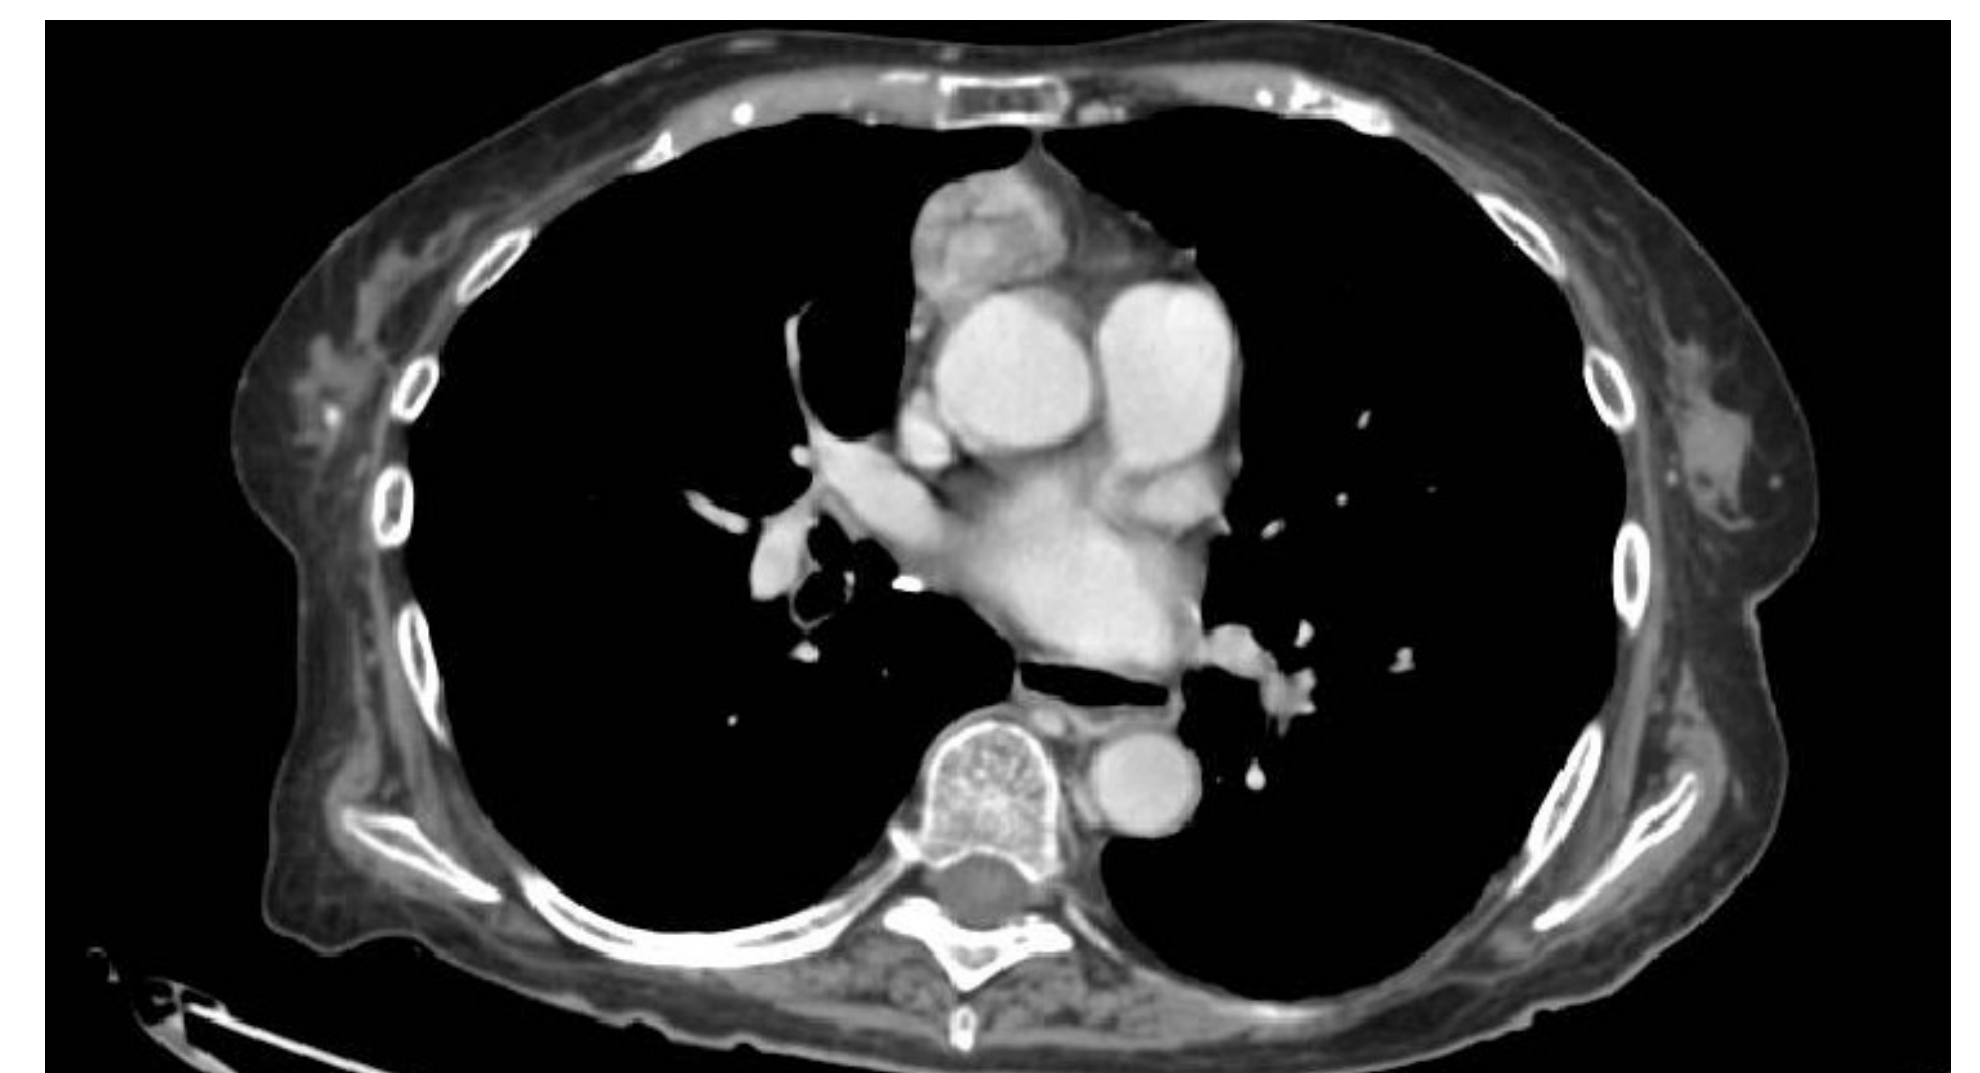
Total-body CT-scan showed thymoma.
